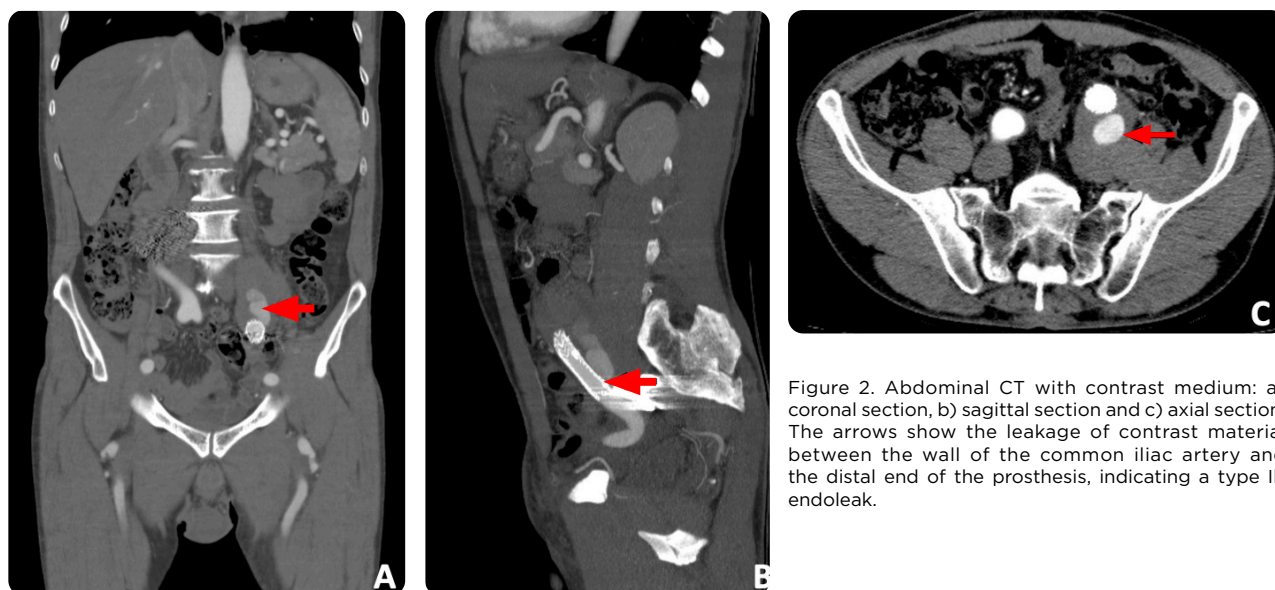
Abdominal CT with contrast medium: a) coronal section, b) sagittal section and c) axial section. The arrows show the leakage of contrast material between the wall of the common iliac artery and the distal end of the prosthesis, indicating a type Ib endoleak.
